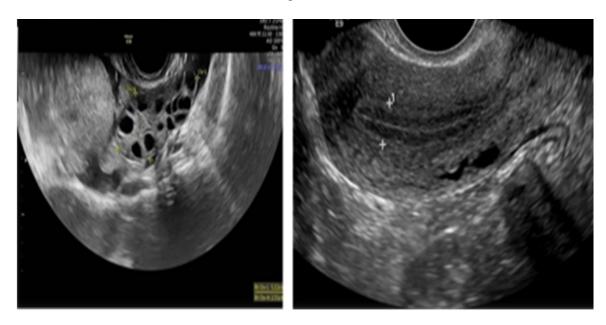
Comparison between a normal ovary and a polycystic ovary using ultrasound [57]
